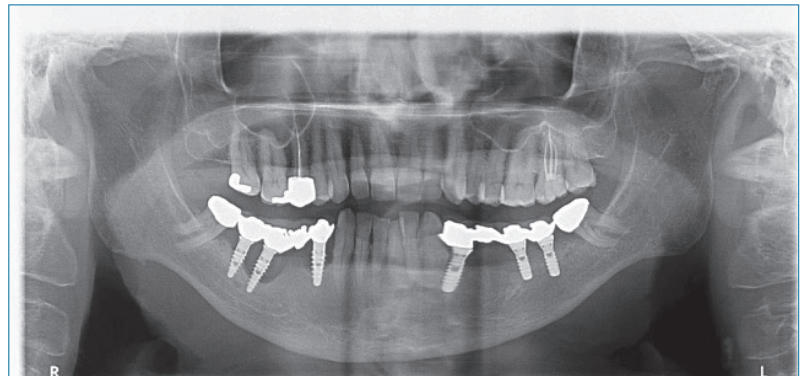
Panoramic x-ray showing failed implant-supported prosthesis in right lower jaw
